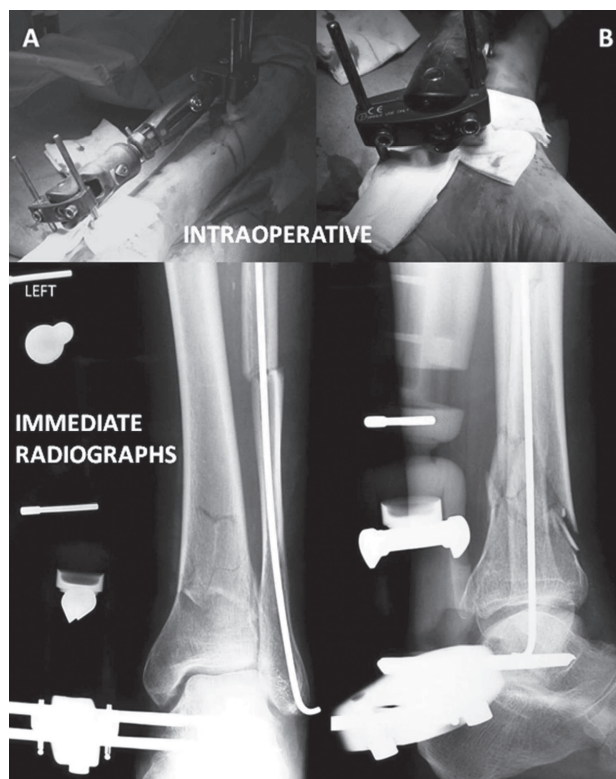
(Top) The Orthofix XCaliber unilateral radiolucent fixator in place with cross ankle joint fixation. Center of rotation is the sinus tarsi. Three self-compressing bone pins are located in the diaphysis of the tibia and two for the ankle are located one in the talus and the other in the heel bone for articulated clamp (A). It is visible in a closer manner the articulated mechanism at the ankle that permits early joint motion (B). (Bottom) Immediate postoperative radiographs. External fixator is radiolucent, hence allowing excellent visualization of the fracture site, where fracture ends are maintained stable in axis. The Steinmann pin is located in the fibula.
